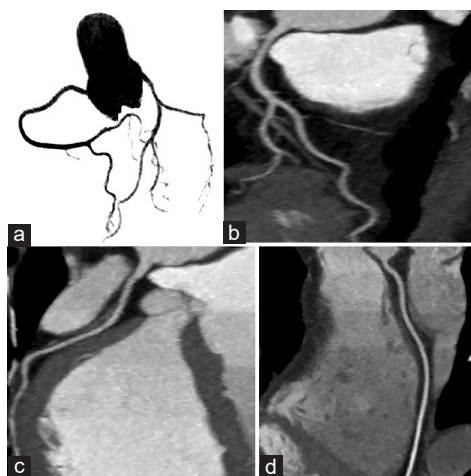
Coronary computed tomography angiography performed at patient's hospital admission, showing no evidence of coronary stenosis (coronary artery disease-RADS 1). Volume rendering with maximum intensity projection image of coronary vessels (a), curved maximum intensity projection reformatted images of left circumflex artery (b), left anterior descending (c), and right coronary artery (d)
